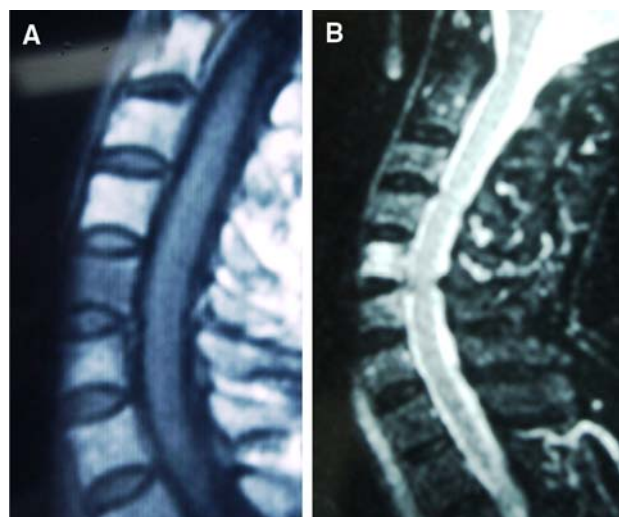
Sagittal MRI of the spine showing discitis at C5–6. There were decreased signal intensity in the adjacent vertebral bodies on the T1-weighted images (a) and increased signal intensity on T2-weighted images (b) adjacent disc spaces
